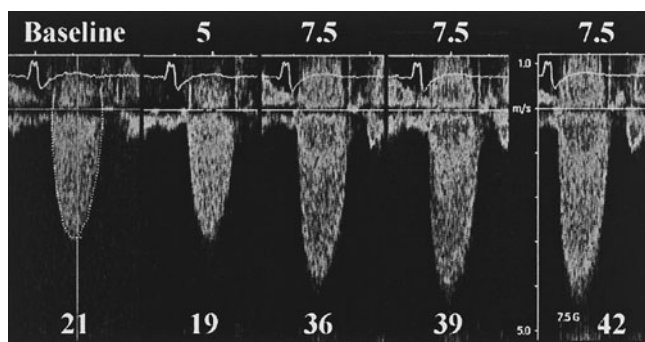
Measurement of aortic velocity by continuous wave Doppler in a patient with severe Aortic stenosis, low ejection fraction, low output and low gradient. The baseline (left) mean gradient was 21 mm Hg and increased (bottom line) with increasing doses of dobutamine (top line). The peak dose was 7.5 μ g/min, and the mean gradient was 42 mm Hg (Courtesy of Dr. Messika-Zeitoun.)
